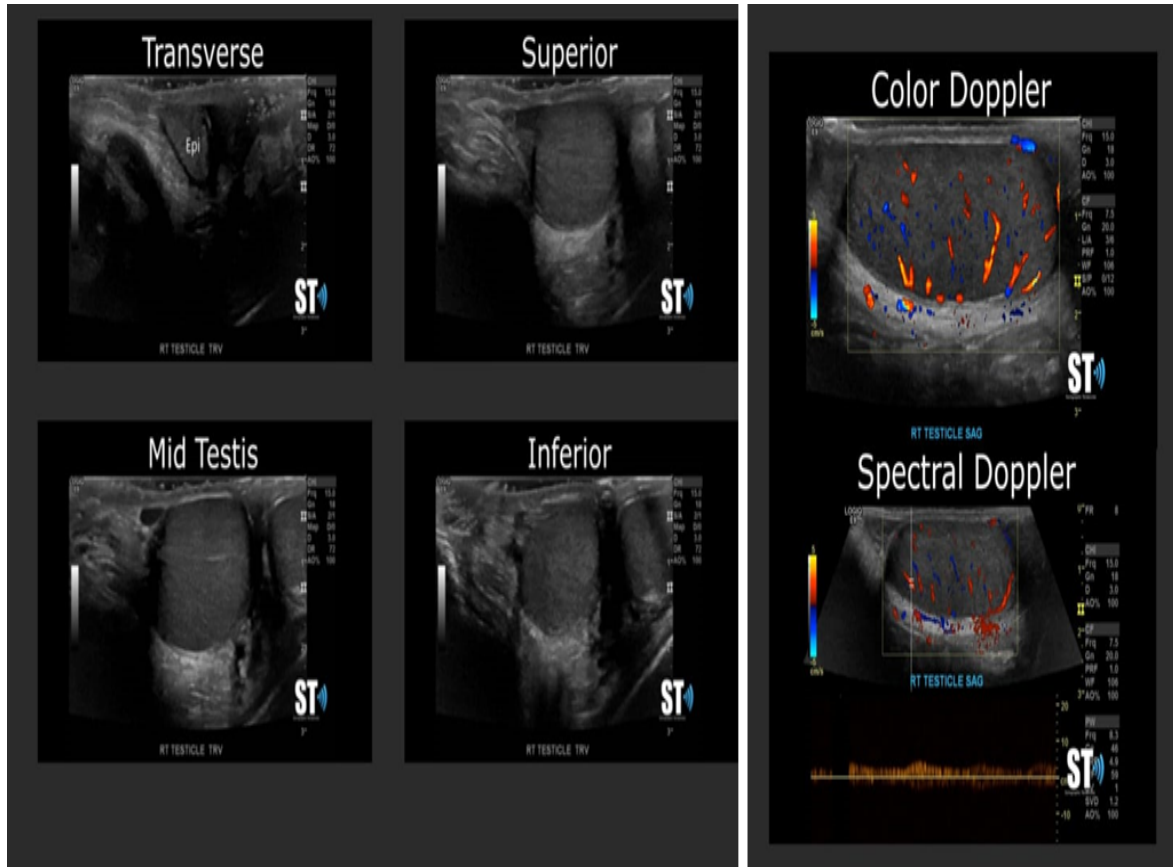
Colour Doppler USG of B/L SCROTUM
